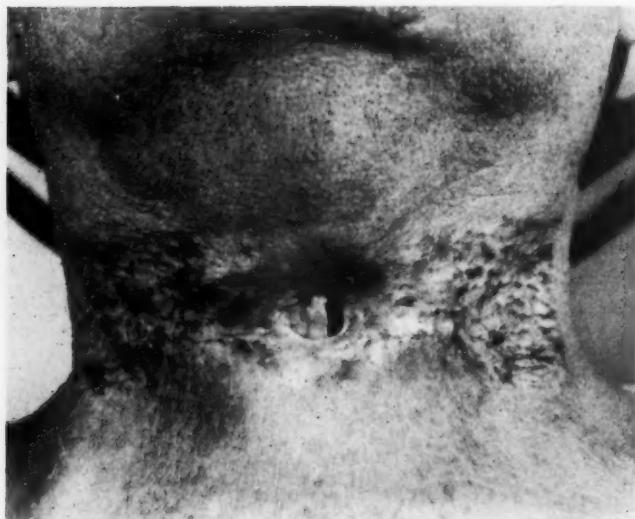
Case H.B., showing neck tissues 12 years after x-ray therapy for laryngeal cancer. Note through and through ulcer and necrotic thyroid cartilage laminae. Atrophy, telangiectasia and pigmentation of the surrounding tissues were severe.
